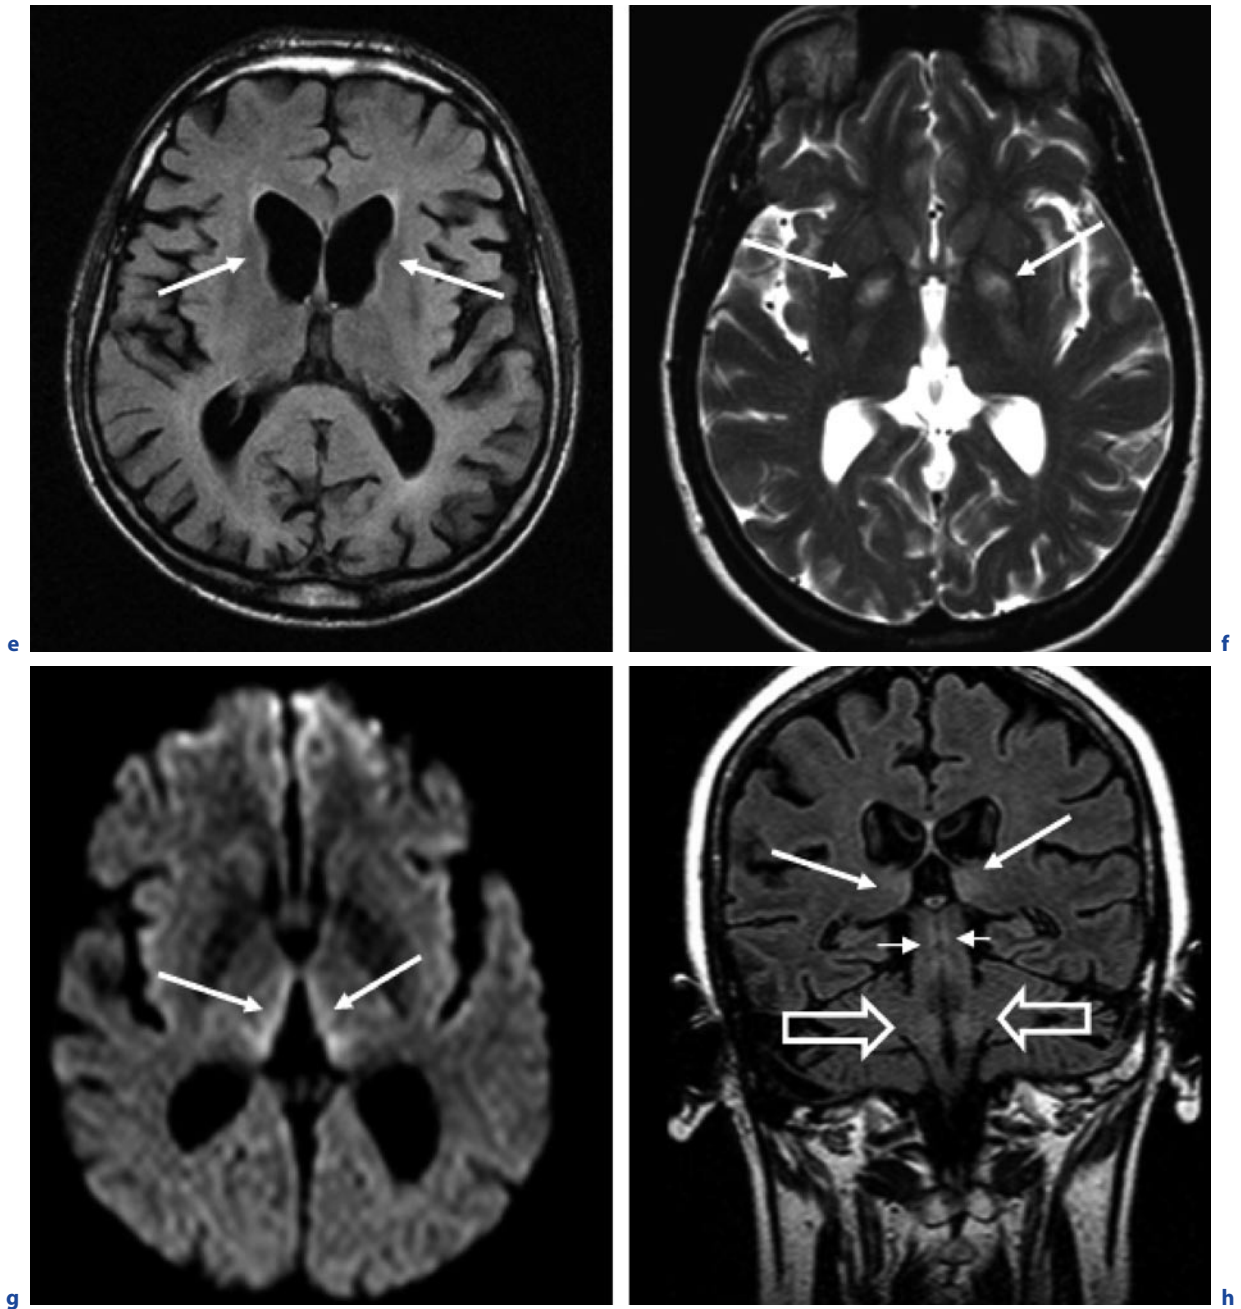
(continued) Diseases mimicking CJD. e Huntington's chorea. Axial FLAIR images. Atrophy of both caudate heads (*arrows*) and consecutive dilatation of the frontal horns of the lateral ventricles. f Carbon monoxide poisoning. Axial T2-weighted image. Bilateral pallidum necroses (*arrows*).
